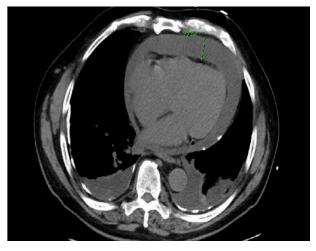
CT scan showing fluid in the pericardial cavity with an effusion of 25.22 mm.
